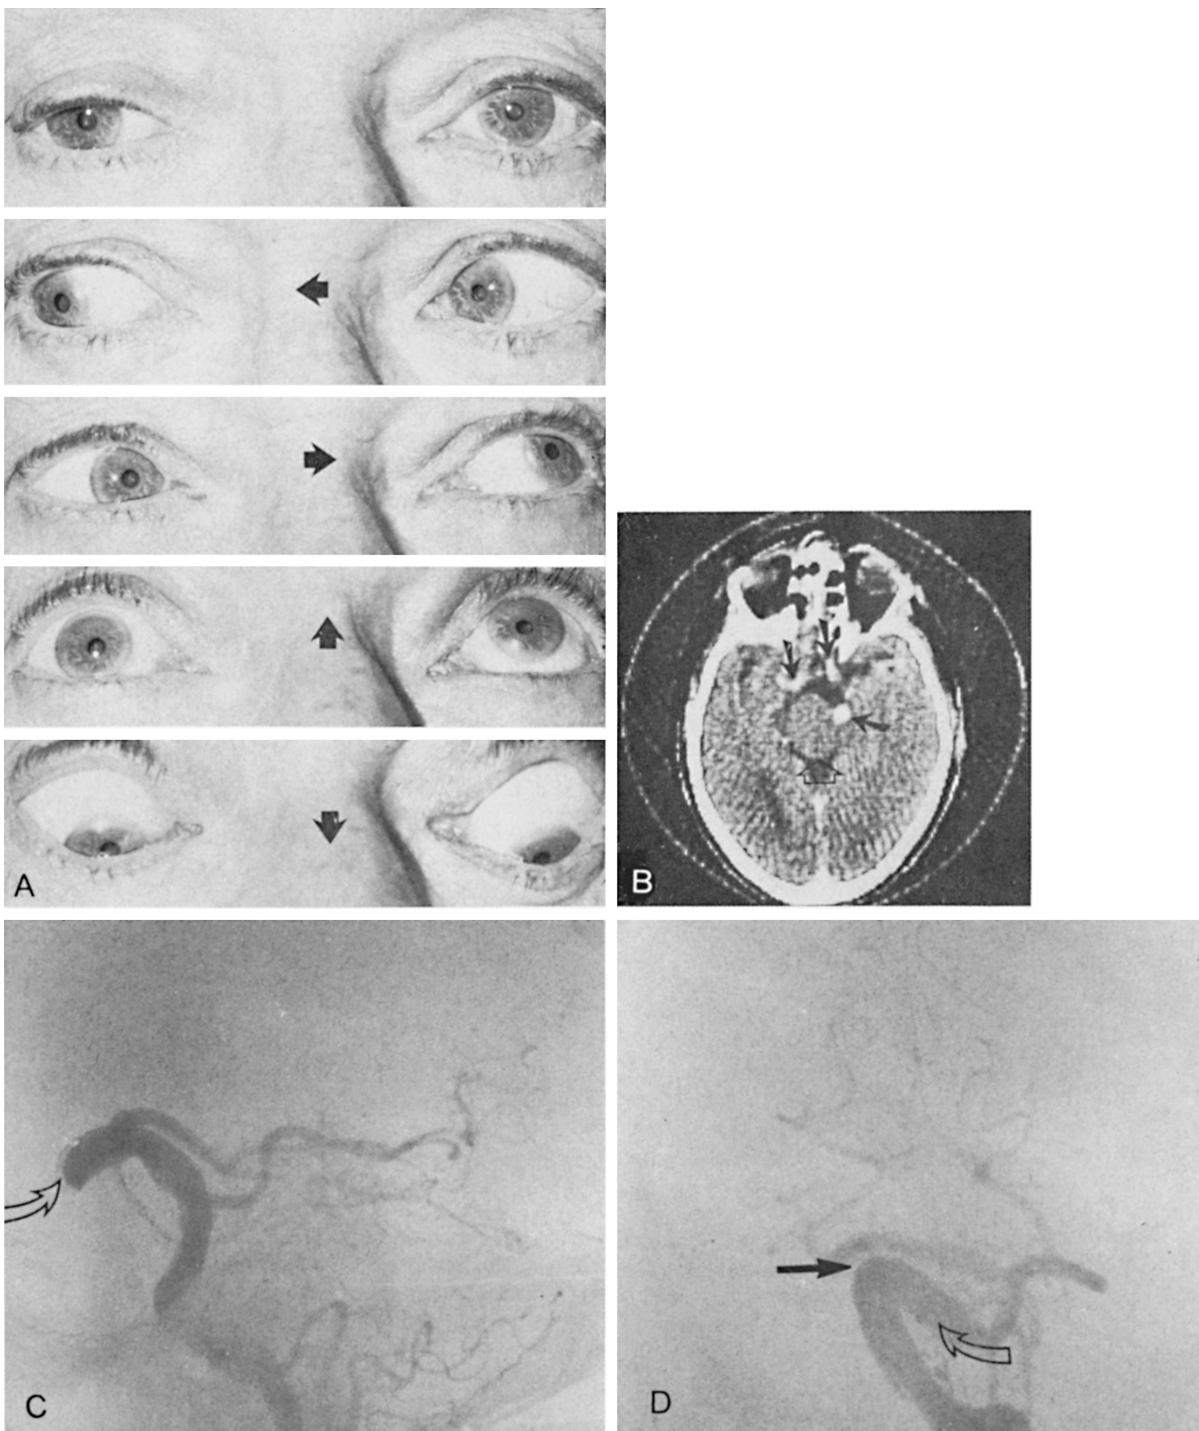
Isolated oculomotor nerve paresis caused by a fusiform aneurysm (*dolichoectasia*) of the basilar artery. The patient was a 61-year-old hypertensive man with a 3-year history of diplopia. *A*, Appearance of the patient shows a moderate right ptosis associated with marked limitation of elevation and mild limitation of depression and adduction of the right eye. The right pupil is the same size as the left. It reacted normally to light and near stimulation. *B*, A CT scan shows small areas of opacification consistent with enlargement of the basilar artery in the perimesencephalic, parasellar, and suprasellar cisterns (*solid arrows*). The brainstem is displaced to the left (*open arrow*). *C* and *D*, Vertebral angiogram, lateral and anteroposterior views, respectively, shows marked dolichoectasia of the basilar artery. At its most distal portion (*solid arrow*), it is causing a mass effect on the right posterior cerebral artery which also is somewhat ectatic and dilated. The anterior portion of the basilar artery extends into the left suprasellar cistern (*open arrows*). (From Trobe JD, Glaser JS, Quencer RC. Isolated oculomotor paralysis: the product of saccular and fusiform aneurysms of the basilar artery. *Arch Ophthalmol* 1978;96:1236–1240.)
